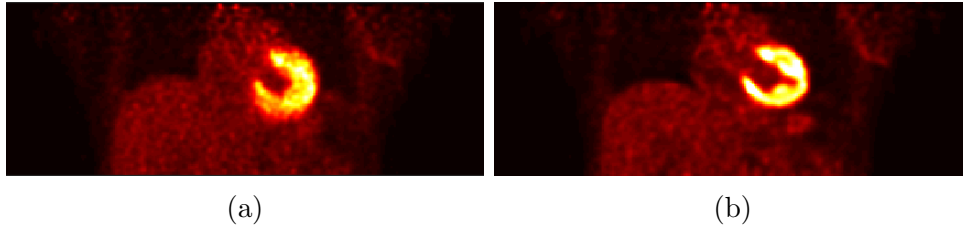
PET coronal slice images reconstructed from Siemens Biograph mMR PET/MRI data: (a) without motion correction and (b) with motion correction. In absence of motion correction, the reconstructed image suffers from motion blur, while the motion blur is significantly reduced in the motion-corrected image. Reprint from Bousse et al. (2017).
